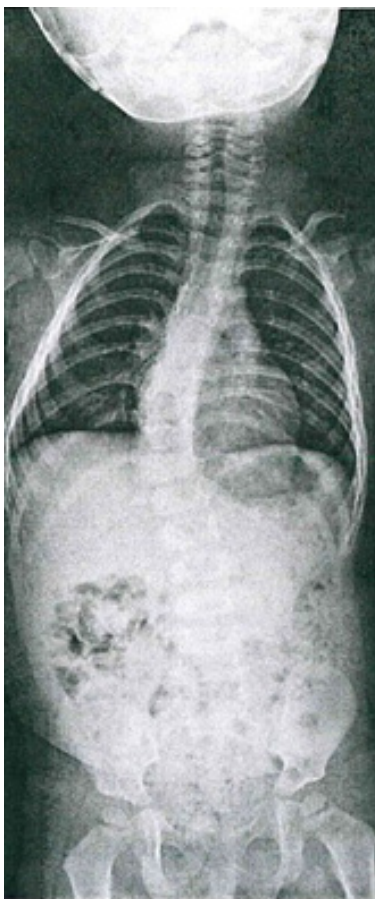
AP X-Ray Prior to First Mehta Cast with Cobb angle
